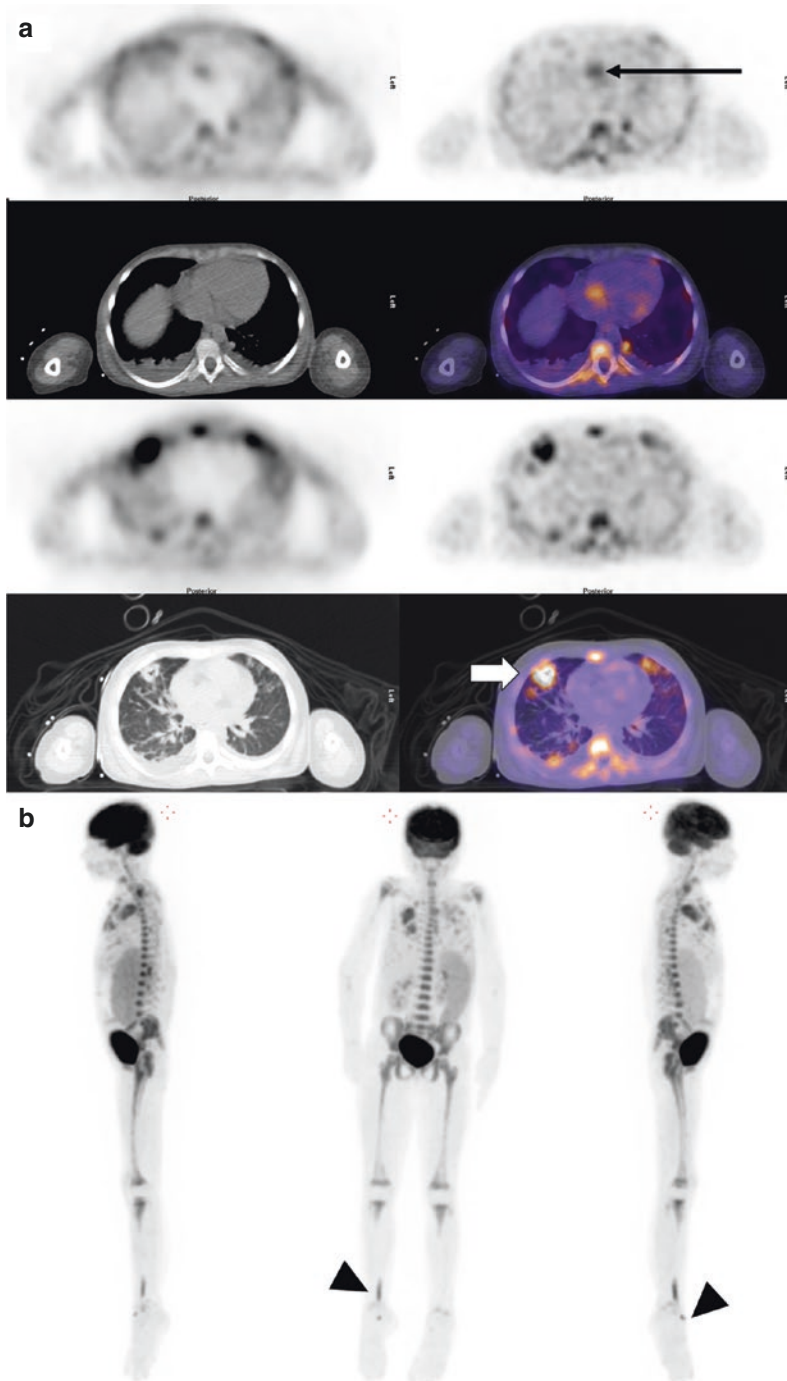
^{18}F -FDG PET/CT of a 10-year-old patient with indwelling central catheter for intravenous hyperalimentation admitted for septic shock. Tricuspid valve endocarditis and lung septic emboli were demonstrated on echocardiogram and chest CT. ^{18}F -FDG PET/CT was requested for the evaluation of left hip pain and performed with myocardial suppression protocol. Selected axial
